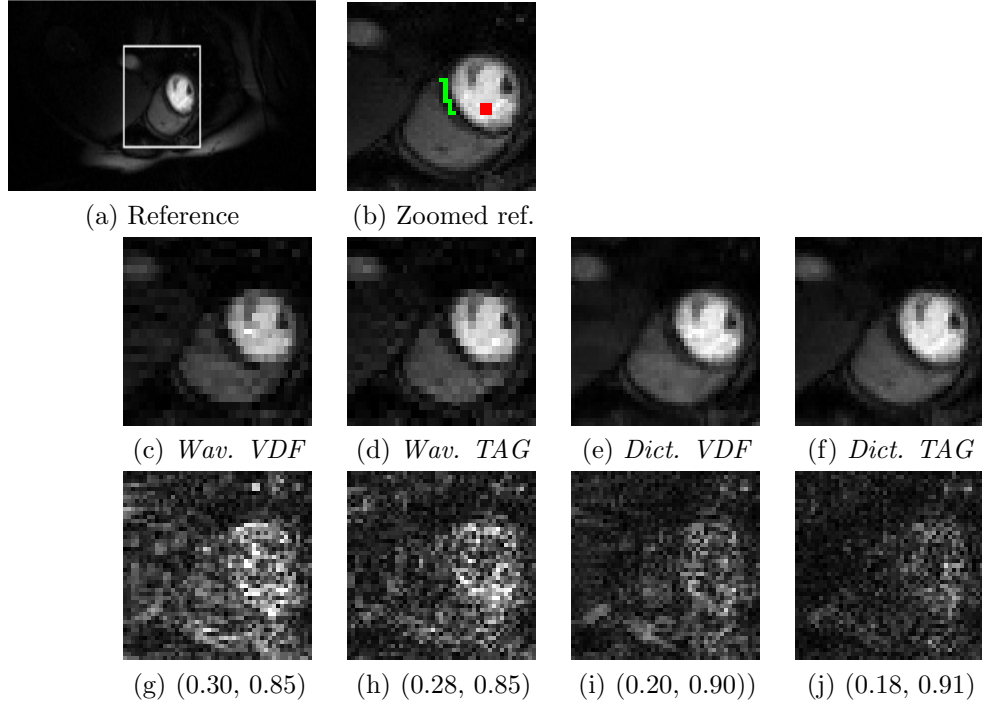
Comparison of image recovery for four different MR image recovery techniques as described in section 3.4.1 at an acceleration factor of $R = 4$. (b) shows a zoomed-in region from the reference image (a). For all other columns, each column shows the zoomed-in recovered and error images for different techniques. Each technique is identified by the text below the recovered images and its performance is reported as pairs (EOF, SSIM) below the corresponding error image.
